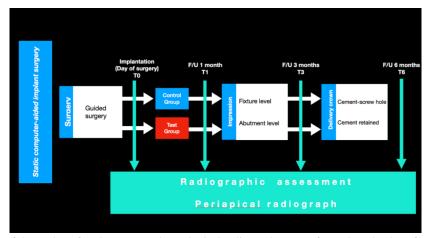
Flow of the study. After the surgery, the periapical radiograph was performed on the day of surgery and at 1-month follow-up, 3-month follow-up, and 6-month follow-up.
